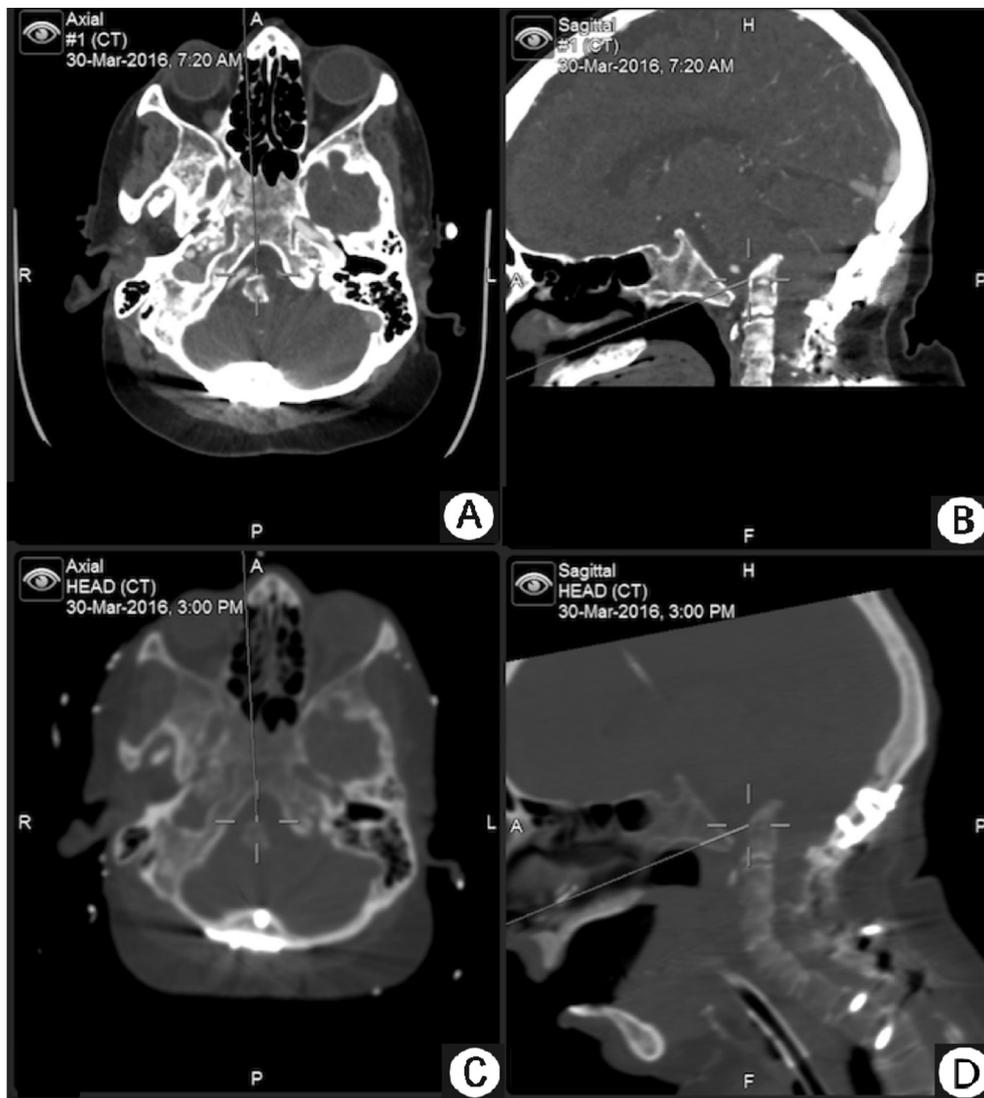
CT Head demonstrates the trajectory of the approach through the nasal cavity. A, C: Axial plane. B, D: sagittal plane.
